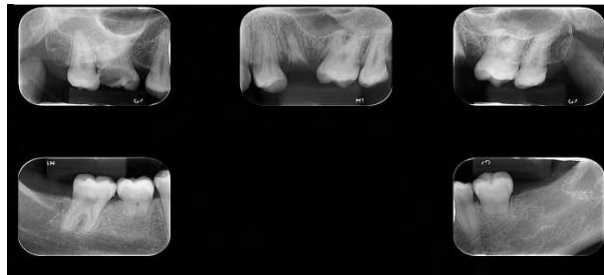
Periapical radiographs 9 years after auto transplantation.
